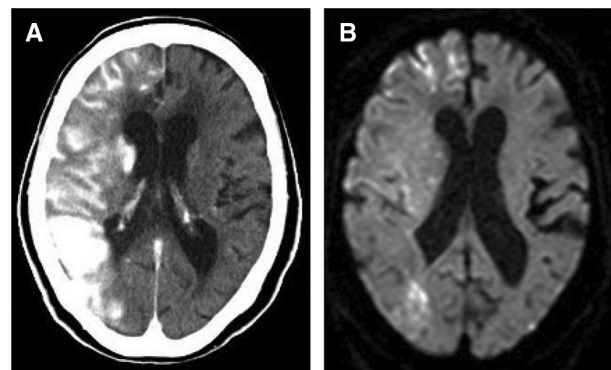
(A) Non-contrast CT findings after second PTA. CT shows extensive contrast medium leakage mainly in the subarachnoid space in the right cerebral hemisphere. (B) DWI shows an HIA in the right cerebral cortex on day 12 (the day after second PTA). DWI: diffusion-weighted imaging; HIA: high-intensity area; PTA: percutaneous transluminal angioplasty
